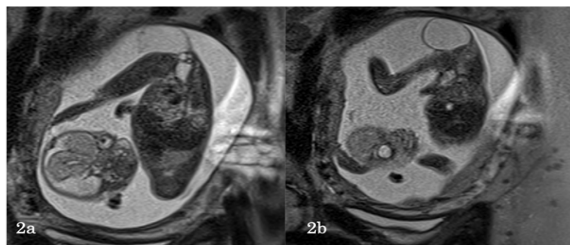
MRI sagittal T2 weighted images showing a large cystic mass with a large extrapelvic component and showing a small intrapelvic component. This mass has predominantly fluid density without any solid component.
